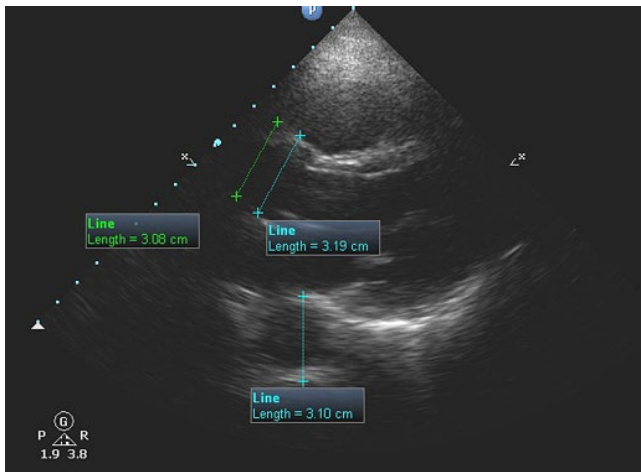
Parasternal long-axis view with measurements at the sinus of Valsalva (3.19 cm), sinotubular junction (3.08 cm) and descending aorta (3.10 cm). Note that, in contrast to the ascending aorta, the descending aorta is measured from one outside-wall to the other outside-wall. The latter method is also used for the abdominal aorta.
